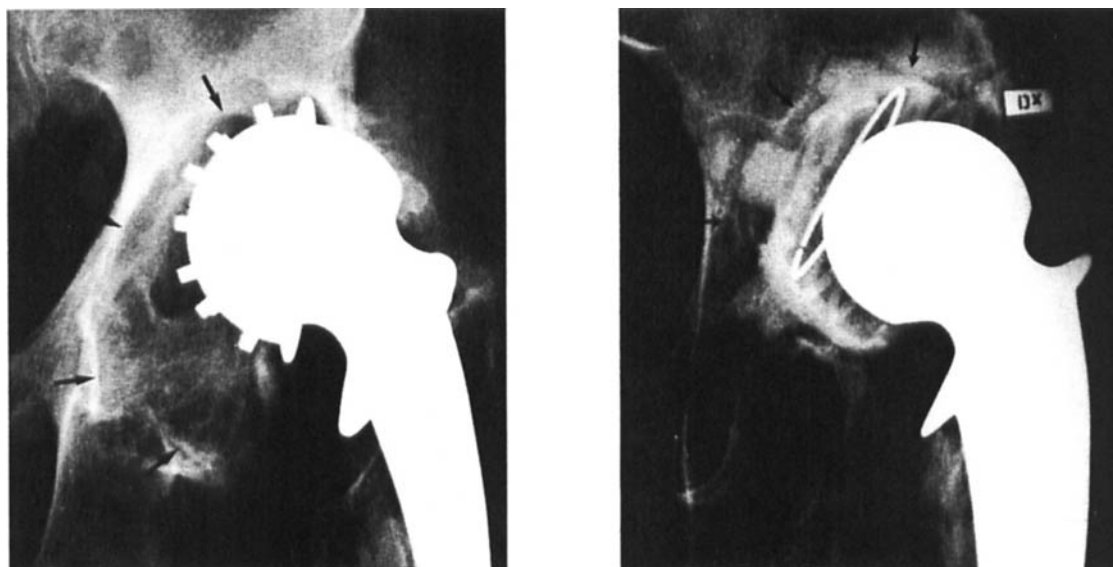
There is an increased risk for mechanical loosening of the acetabular component following revision of the hip to the left (Type III) compared with the right hip (Type II). The left AP radiograph shows a defective superior wall, probably requiring a bone graft. In the right radiograph, there is marked enlargement and thinning of the acetabular wall, but no wall defect. The lateral projections, not shown here, did not reveal any wall defects.
